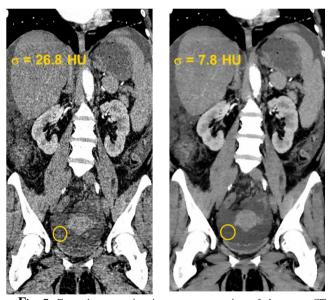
Example comparing image reconstruction of the same CT dataset using (left) standard filtered back-projection (FBP) and (right) iterative reconstruction with SAFIRE. The dataset corresponds to a abdomen-pelvis examination of an adult patient. The image reconstructed with SAFIRE exhibits a lower noise, better CNR at maintained spatial resolution compared to the same image reconstructed with standard FBP.
